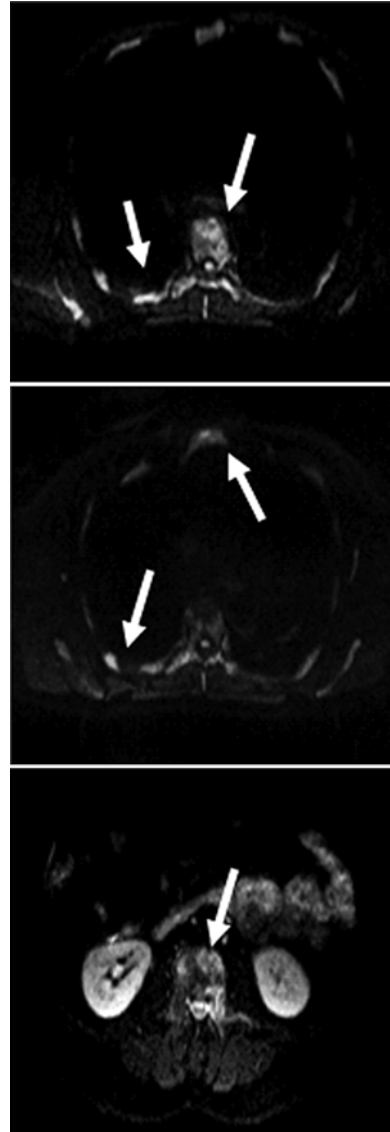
A 64-year-old male with diffusely metastatic prostate cancer. Multiple foci of restricted diffusion on axial images from WB-DWI ($b=800$) within the ribs, sternum, and spine compatible with metastases (arrows). Courtesy of Michael A. Jacobs, Ph.D. (JHU)
